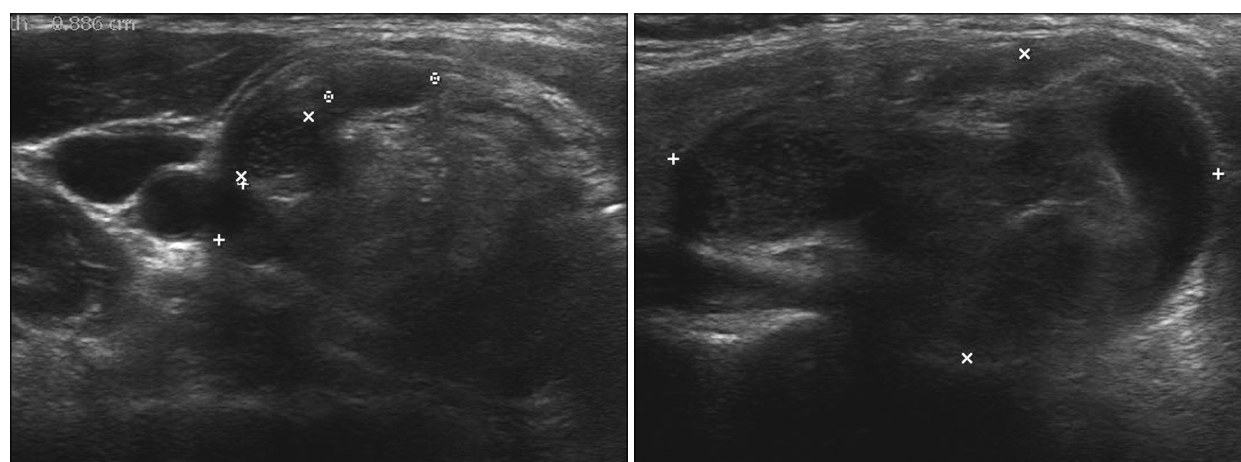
Ultrasonographic scans showing right lobe was mostly occupied with a solid nodule of 44×23×25 mm with markedly inhomogeneous hypoechogenicity and hyperechoic lesion.
